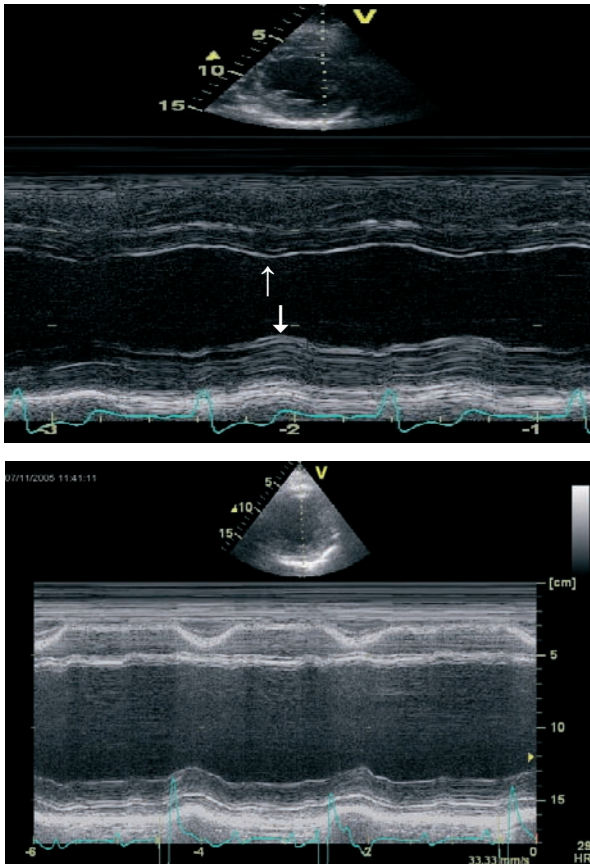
Panel A:* Measurement of the septal to posterior wall motion delay (SPWMD) using M-mode echocardiography. An M-mode recording through the (antero-) septum and posterior LV wall is obtained in the parasternal short-axis view. LV dyssynchrony is defined as the shortest interval between the maximal systolic displacement of the septum and the maximum systolic displacement of the LV posterior wall. Arrows indicate maximal systolic displacement. *Panel B:* Patient example in which assessment of LV dyssynchrony was not feasible with M-mode echocardiography due to akinesia of the antero-septal wall.
